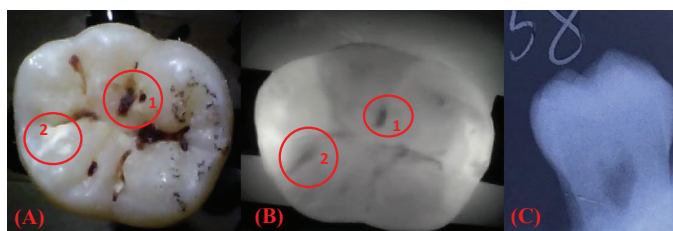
Sample 6 under visible light (A), NIR light (B), and X-ray (C).
